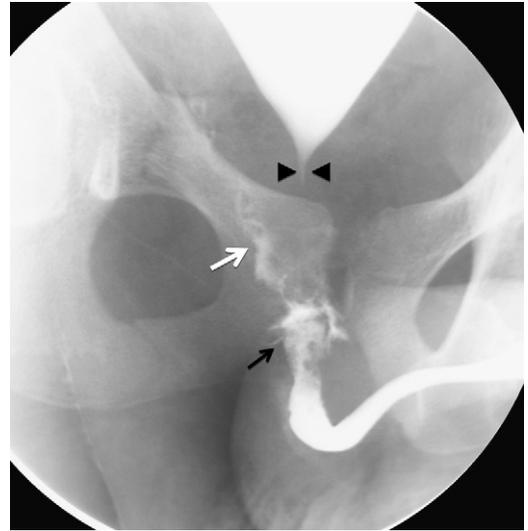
Type III urethral injury. In this patient there is posterior urethral injury extending through the urogenital diaphragm to involve the bulbous urethra. Retrograde urethrograms reveal contrast material extravasation at and below the membranous urethra (*black arrow*) and a component above the urogenital diaphragm (*white arrow*). Complete disruption of the membranous urethra was diagnosed. Urethral transection results in dislocation of the bladder superiorly, which in this case is filled with excreted contrast from a prior contrast-enhanced CT scan. Note the narrowed and elevated bladder base (*arrowheads*) because of pelvic hematoma.
